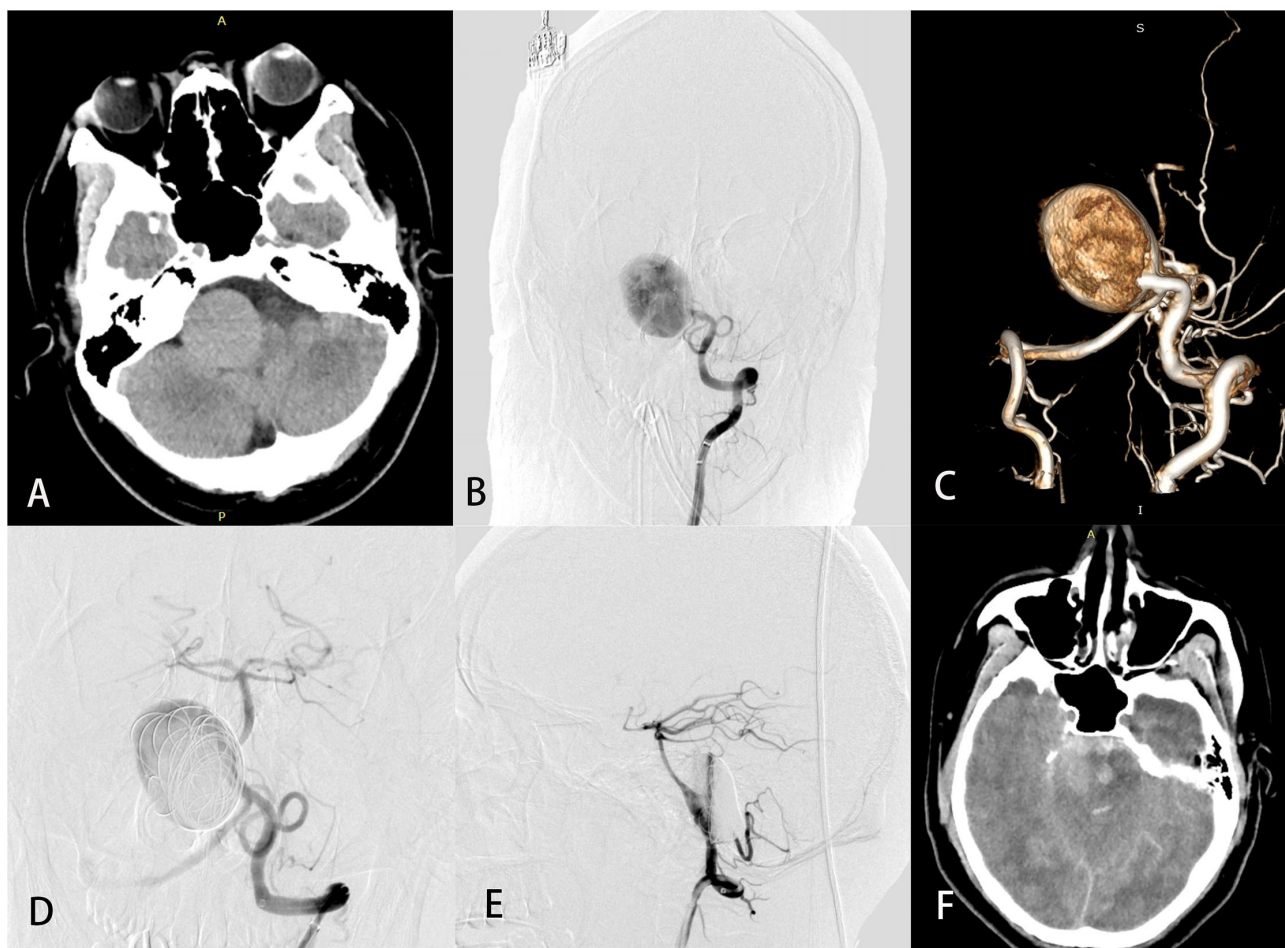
A 26-year-old man (case 29) with a giant basilar artery aneurysm presented with tinnitus. Preoperative computed tomography (A) showed a large mass in the right anterior brainstem. Preoperative angiography (B) with 3-dimensional reconstruction (C) showed a giant side wall saccular aneurysm of the proximal basilar artery. Anteroposterior (D) and lateral (E) views of left vertebral angiography demonstrated excellent reconstruction of the basilar artery and contrast stasis in the lumen of the aneurysm. Computed tomography (F) on postprocedure day 3 was obtained to evaluate headache, vomiting, and disturbed consciousness and revealed massive subarachnoid hemorrhage. The patient later died.
